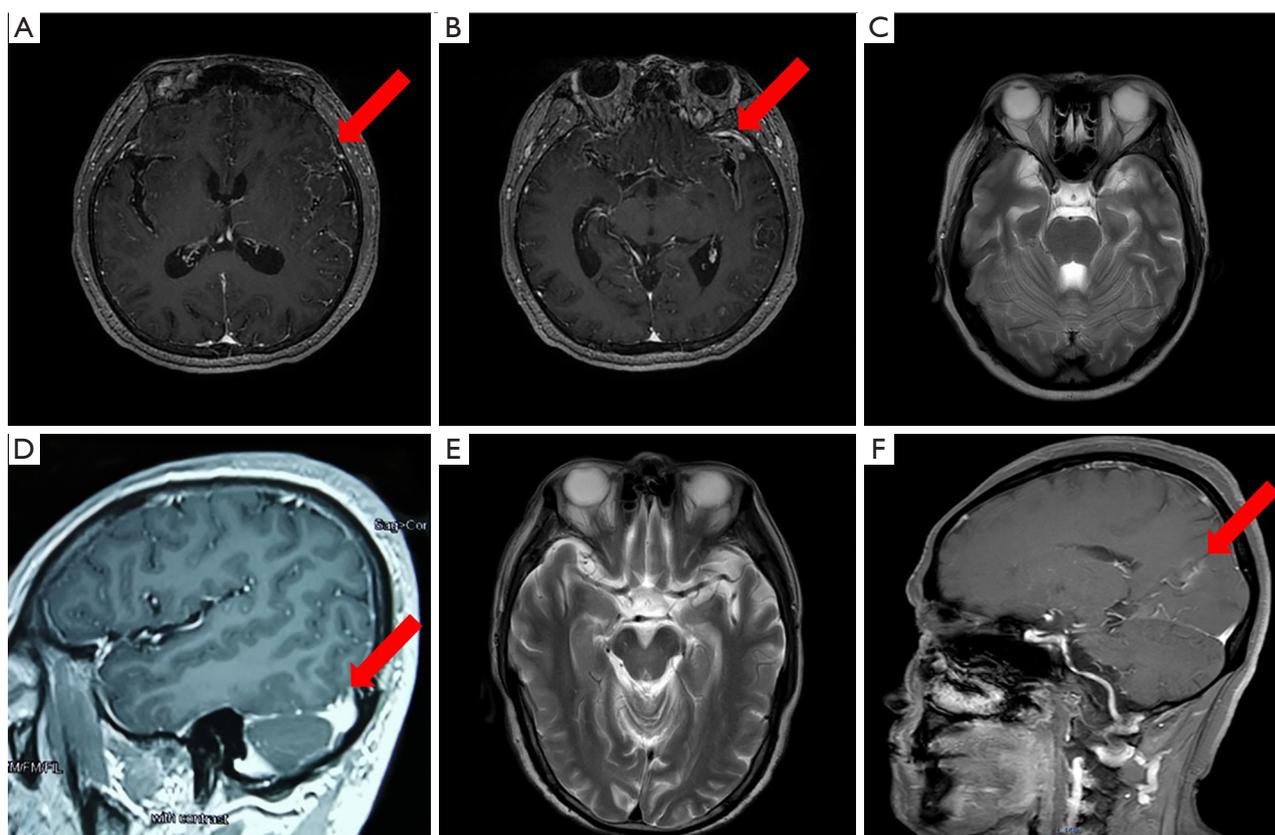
Brain MRI: abnormal line-like enhancement can be seen in the leptomeningeal of both temporal lobes (A,B). None abnormal enhancement lines in leptomeningeal and brain parenchyma, none hypodense edema area (C). Multiple enhancement lines in both cerebellar sulci (D). Cerebral ischemia in periventricular area, none abnormal enhancement lines in leptomeningeal and brain parenchyma (E). Small patched enhancement in occipital lobe (F).
